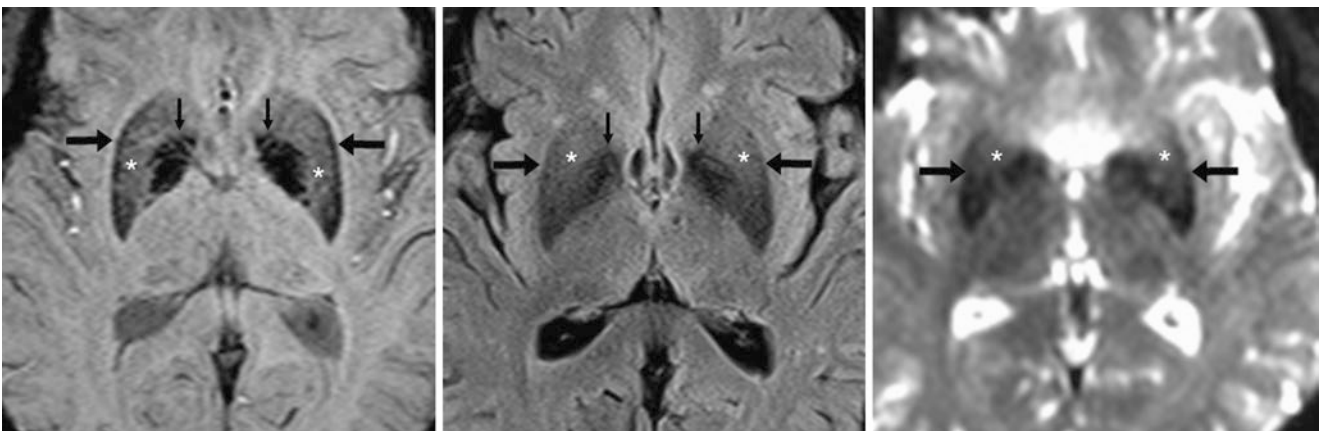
A 63 year old in whom 3T MRI SWI (*left*) and FLAIR (*middle*) depict iron throughout the lentiform nuclei, being most prominent within the GP but even darker within the medially located GP interna (*thin arrows*). Iron is less prominent within the medial putamina (*) but is more prominent along the lateral edge of the putamina (*arrows*). Note corresponding findings on b=0 map from DWI (*right*), which is a single echo echoplanar sequence that has T2-weighting but also T2* effects, as DWI is usually obtained by a single echo, gradient echo sequence
